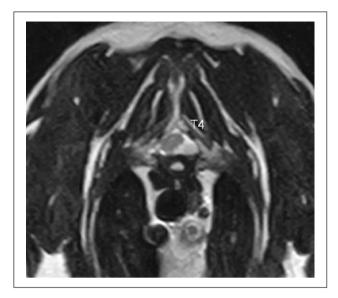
MRI scan, T2-weighted, transverse plane: a leftsided extradural lesion at the T4 level, with a hyperintense pattern (relative to spinal cord). Note the dorsal and contralateral spinal cord displacement (case 2)
